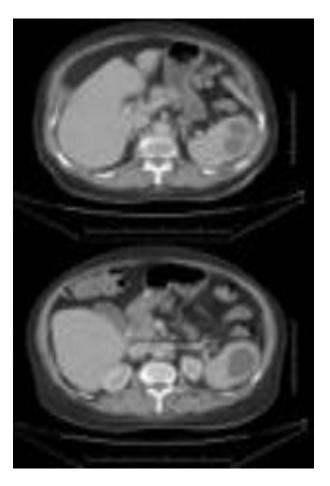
Contrast-enhanced CT scan showing splenomegaly with multiple hypodense cystic lesions.
